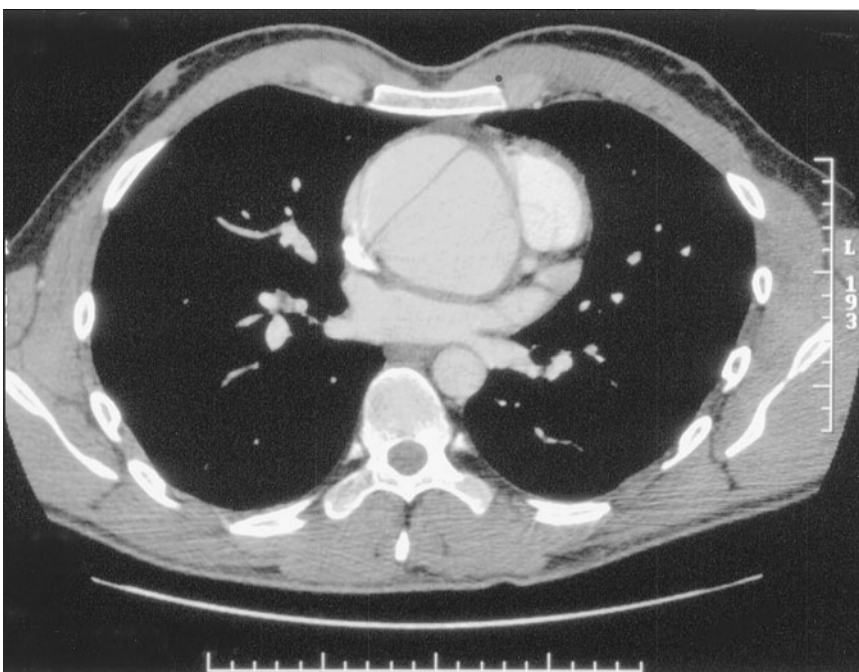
Axial image of CT arteriogram of acute type A dissection showing a dissection flap in the mid-ascending aorta.
